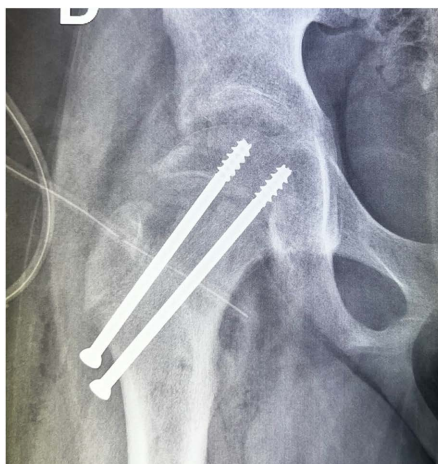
Postoperative radiograph showing satisfactory reduction maintained with two screws.
